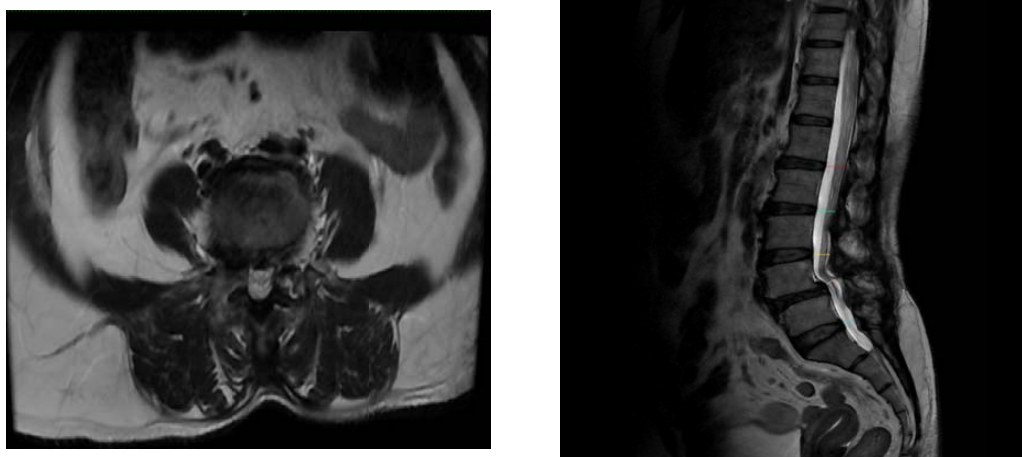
Axial T2-weighted and Sagittal T2-weighted images of the lumbosacral spine demonstrate Grade I anterolisthesis of L4 over L5 with bilateral facet joint arthrosis. Anterior endplate osteophyte formation is noted. At the L4–L5 level, a posterior disc-osteophyte complex is seen causing ventral thecal sac indentation with associated bilateral neural foraminal and lateral recess narrowing, resulting in compression of the right and indentation of the left exiting L5 nerve roots.
